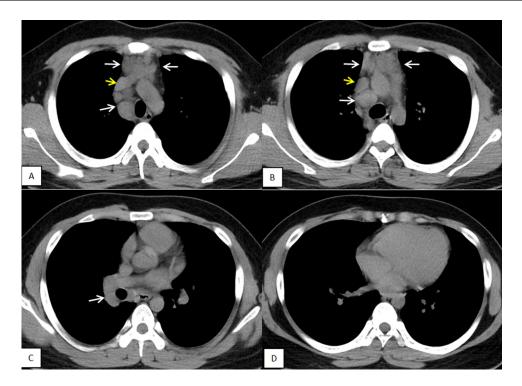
Chest CT, anterior mediastinal window with intravenous contrast (slices from top to bottom).
